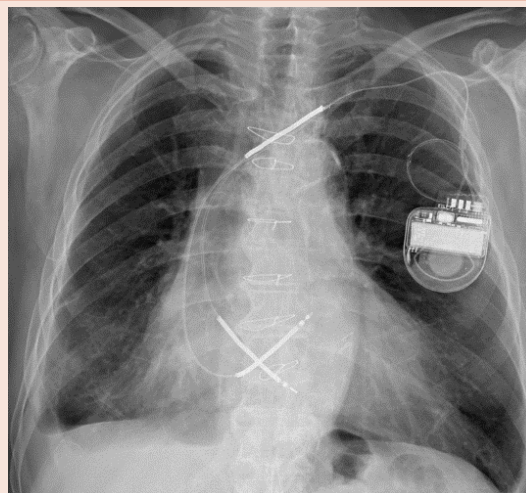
At six-months X-ray, the lead tip is stable in the position reached after percutaneous repositioning.
